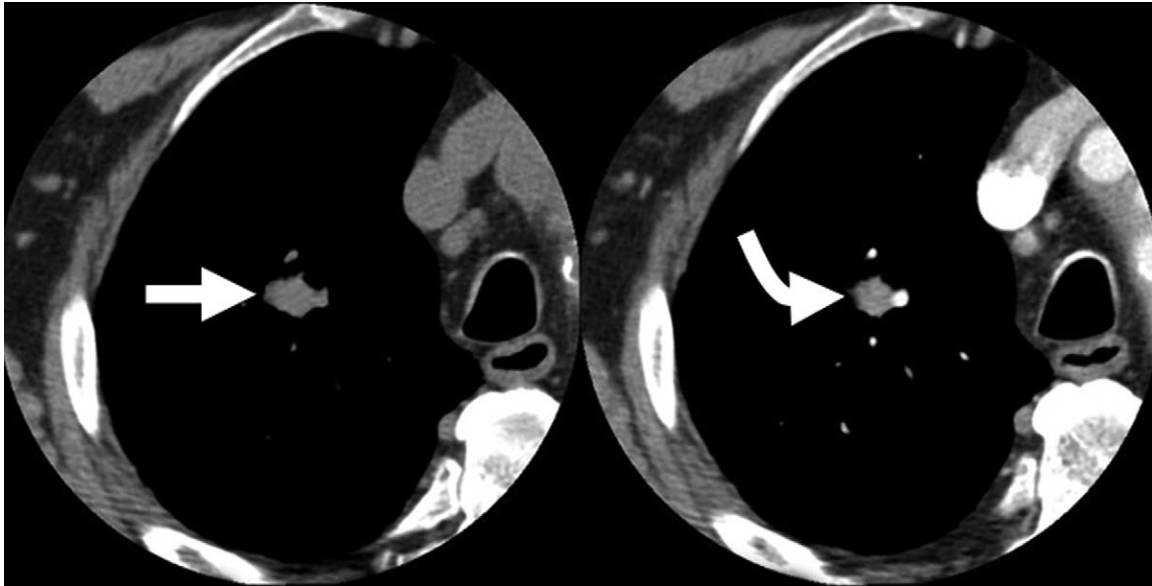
Dynamic contrast-enhanced CT: lung cancer. A 71-year-old subject with a suspicious pulmonary nodule. Thin-section CT images through the nodule before (arrow) and after (curved arrow) bolus administration of iodinated intravenous contrast material showing enhancement of the nodule. The difference in density between the precontrast image and the maximum enhancement image was 30 HU. The nodule was resected, and found to be grade 3 pulmonary adenocarcinoma.
